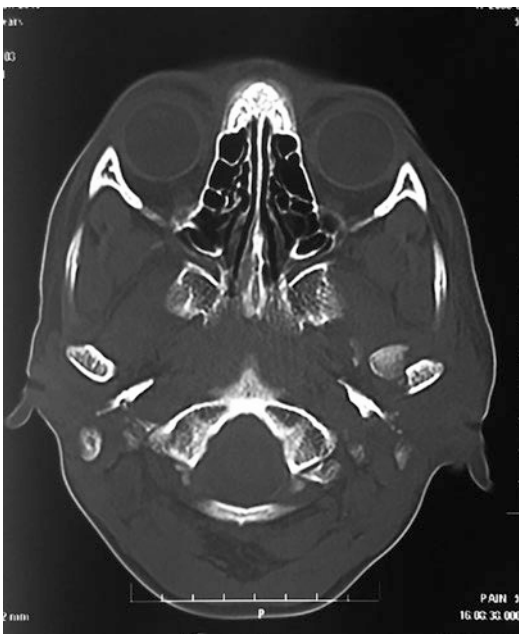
Computed tomographic (CT) scan of a patient with a sagittal fracture of the mandibular condyle
